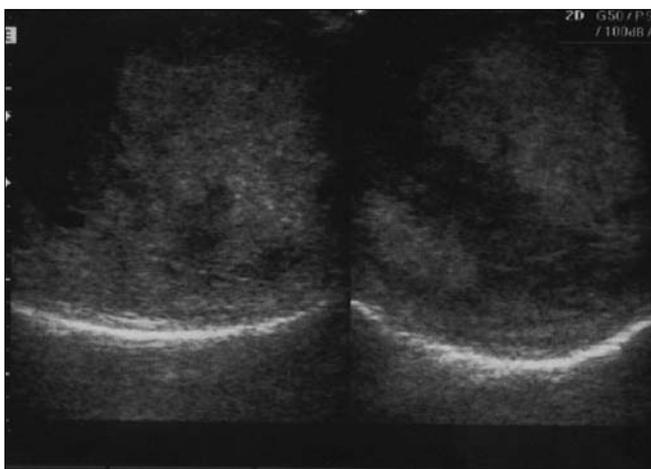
Tumor of the testis (mucinous cystadenocarcinoma) – ultrasound scan.
